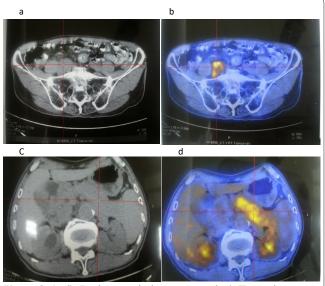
(a-d): Positron emission tomography/CT scan image.
